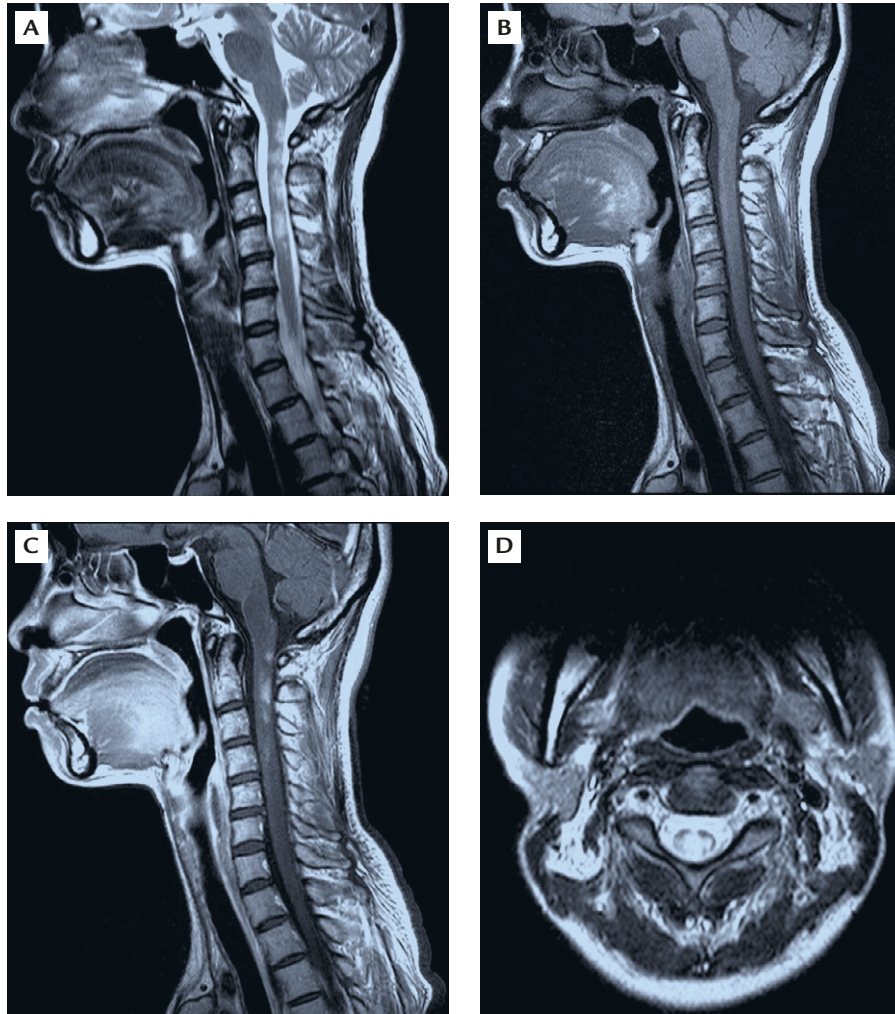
Cervical spinal magnetic resonance imaging (1 month after onset of herpes zoster). Multiple expansive intramedullary lesions with: (A) high signal intensity on sagittal T2-weighted images; (B) low signal intensity on sagittal T1-weighted images; (C) enhanced on post-contrast medium T1-weighted images; and (D) axial T2-weighted images were demonstrated. Jumping lesions were found at the level of C1 to C5, with focal edematous change.
